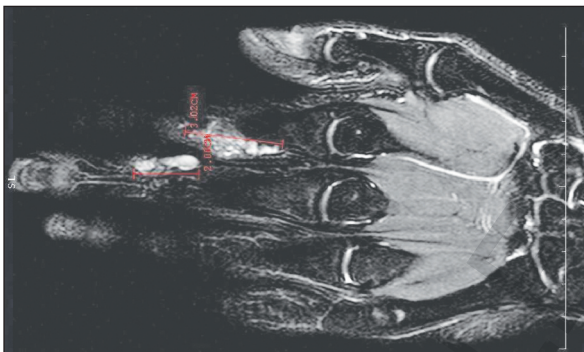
Coronal section magnetic resonance imaging of the patient's left hand, showing the malformed venous structures in the 2nd and 3rd finger
